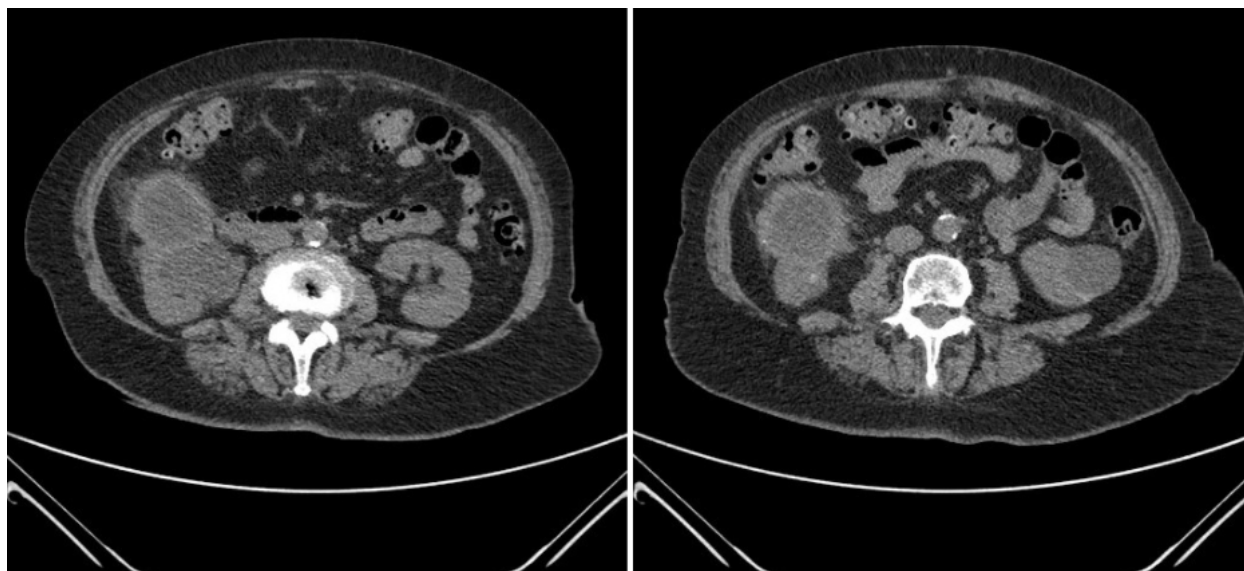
Abdominal CT one-month post surgery.
